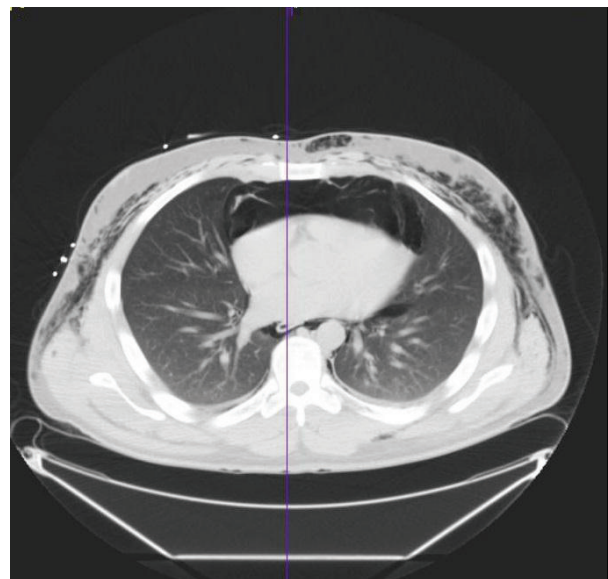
Axial view of CT chest revealing extensive pneumomediastinum and subcutaneous emphysema.
